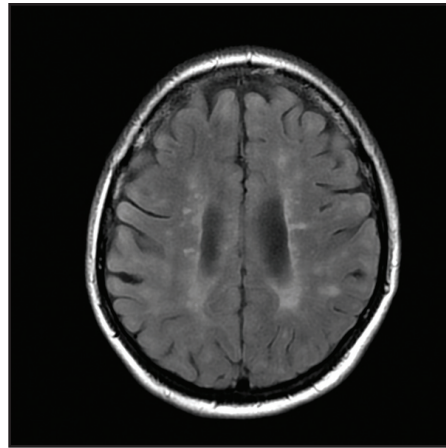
(A) Axial T1-weighted MRI post-gadolinium demonstrates enhancing white matter lesions bilaterally. (B) Axial T2-weighted MRI shows periventricular multifocal hyperintense white matter lesions consistent with demyelination.
